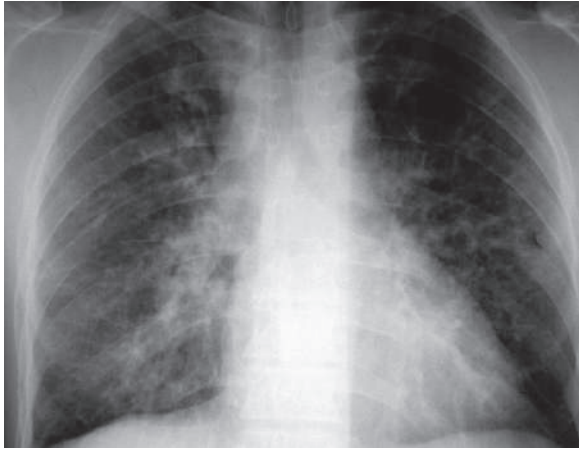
Posteroanterior chest radiograph of a patient with grade 3 pulmonary sarcoidosis shows bilateral diffuse reticular interstitial pattern due to lung fibrosis
